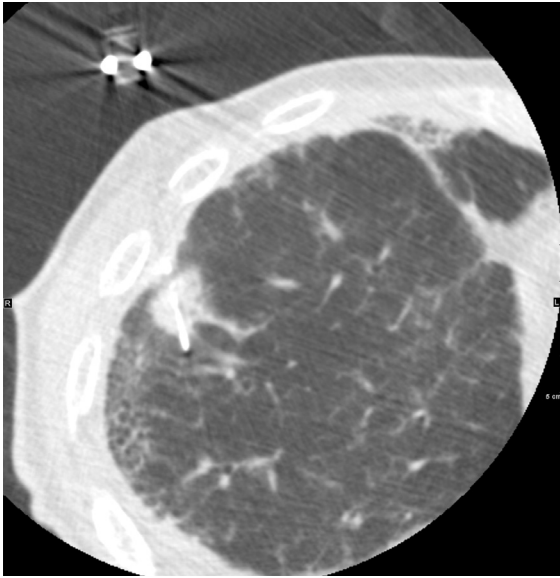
Computed tomography (CT) during biopsy. A CT-guided lung biopsy was performed for a pulmonary nodule in the right lower lobe.
